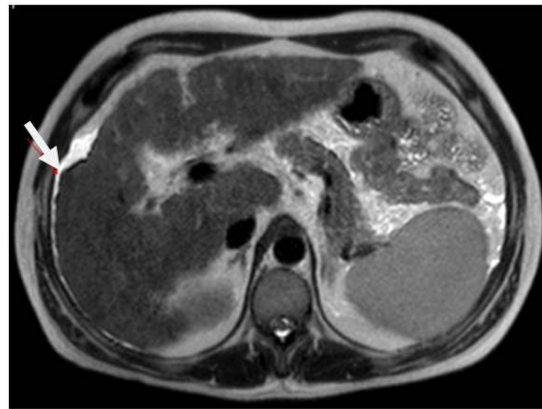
Dysplastic nodule – MRI axial T2 The same lesion shows slight hypointensity on T2 TSE. It is also evident the presence of perihepatic fluid
